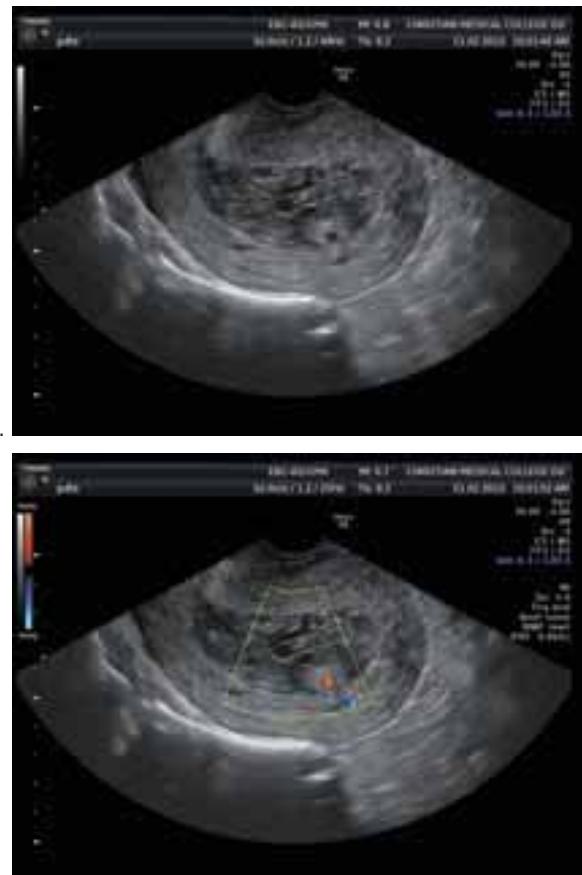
Ultrasonographic images of retained placental tissue. a. Placental tissue visible in the uterine cavity. b. Color Doppler shows vascularity in the periphery of the tissue.
